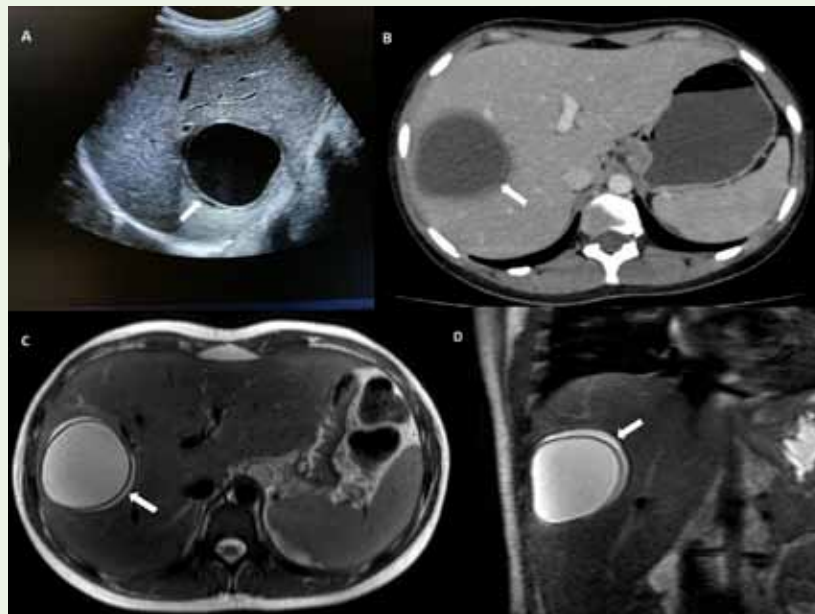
Case of a 19-year-old female with right hypochondriac pain: Ultrasound image of the liver (Image A) shows an anechoic double-walled cystic lesion – ‘Double line sign’ (marked by white block arrow). Image B is the axial section of the contrast-enhanced CT abdomen of the same patient showing a rounded well-defined non-enhancing hypodense double-walled cystic lesion (marked by a white arrow). Axial (Image C) and coronal sections (Image D) of the T2-weighted MR sequence reveal a similar double-walled (marked by a white arrow) hyperintense cystic lesion in the right lobe of liver.
